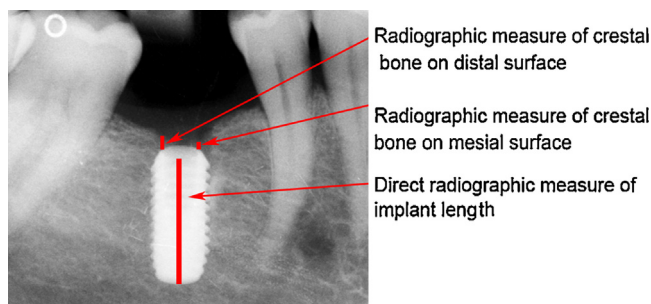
Direct measurements on a standardized, digital peri-apical radiograph at the time of implant placement (T0). To ensure measurements were calibrated, an object of known size was placed in the image on the same plane as the implant. To adjust the measurements for magnification error, the following equation was used to determine the corrected crestal bone levels: corrected crestal bone level = measured crestal bone level  $\times$  (actual implant length, e.g. length of implant based on manufacturing standards/measured implant length).
